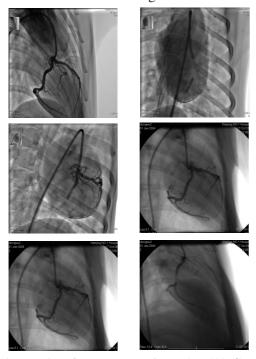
Results of coronary angiography. (A) Coronary artery in coronary angiography before stent implantation. (B) Implantation of first stent. (C) Implantation of second stent. (D) Coronary artery in Coronary angiography after operation. (E) Coronary angiography at 4 weeks after surgery. (F) Intravascular ultrasonography at 4 weeks after surgery.
